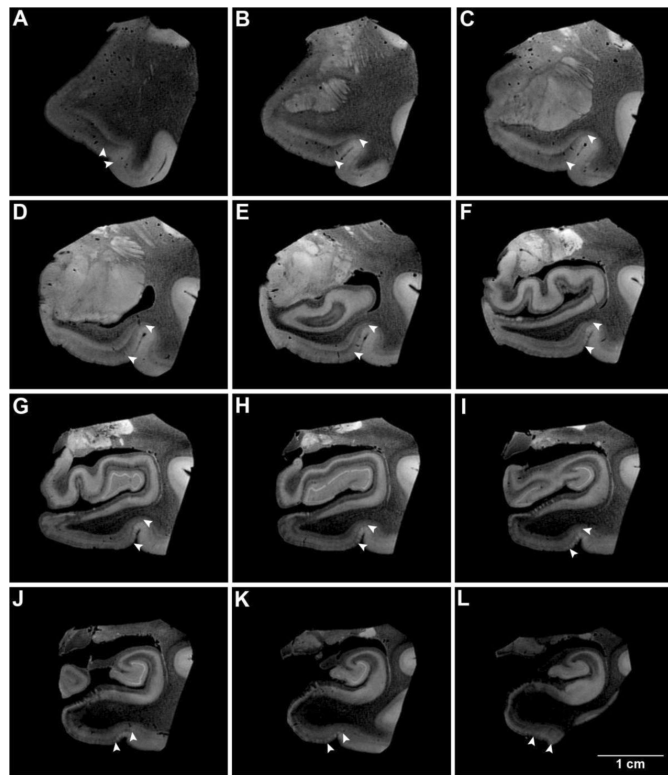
Anterior-posterior coronal slices that demonstrate perirhinal cortex in *ex vivo* MRI. Several *ex vivo* MRI slices demonstrate detection of perirhinal cortex (area 35) throughout its rostrocaudal extent in one selected case (67 year old, male). Note the vertical columnar structures in 35a and the oblique wedge in entire area 35 that indicate perirhinal cortex. White carets represent the medial and lateral borders in panels A–L.
